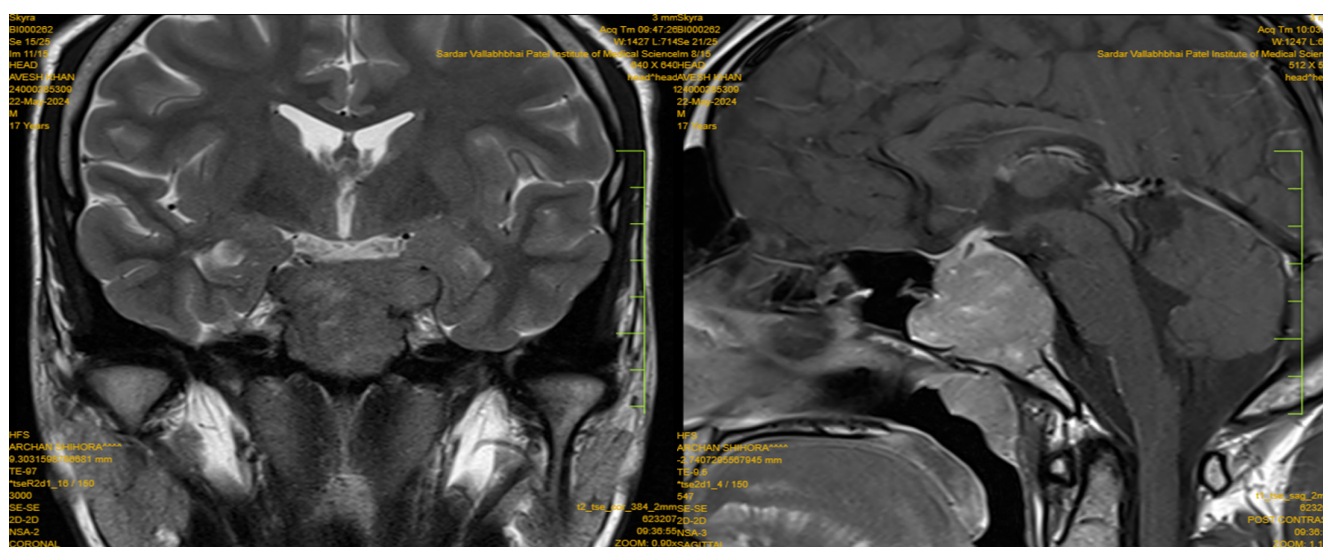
MRI images revealed a well-defined extra-axial lobulated solid lesion isointense in T1 and T2 weighted sequences with few peripheral areas of GRE blooming (calcification).
